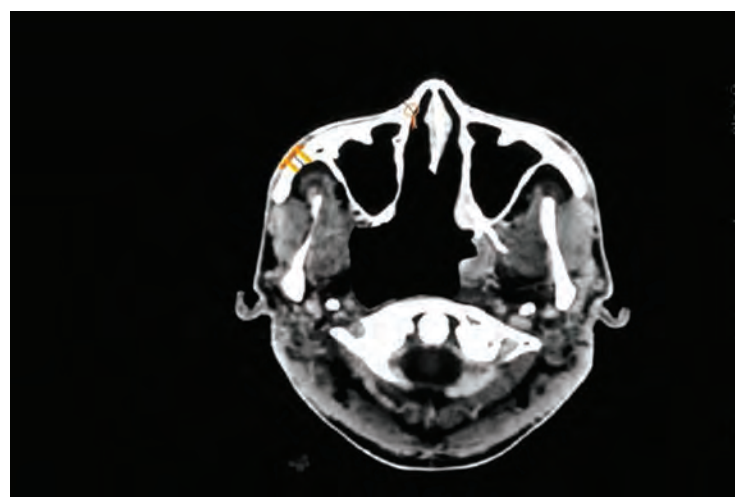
A CT scan showing a recurrent nasopharyngeal carcinoma. (Courtesy William Wei, MD.)
